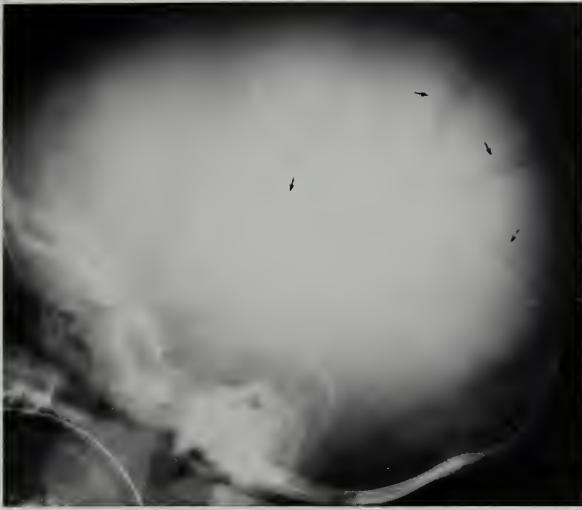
This 3-month female presented in the Emergency Room with cardiorespiratory arrest, and subsequently died. Chest radiography showed multiple rib fractures of varying age and this skull film revealed multiple fractures (arrows). These findings were key evidence in the litigation that followed.
